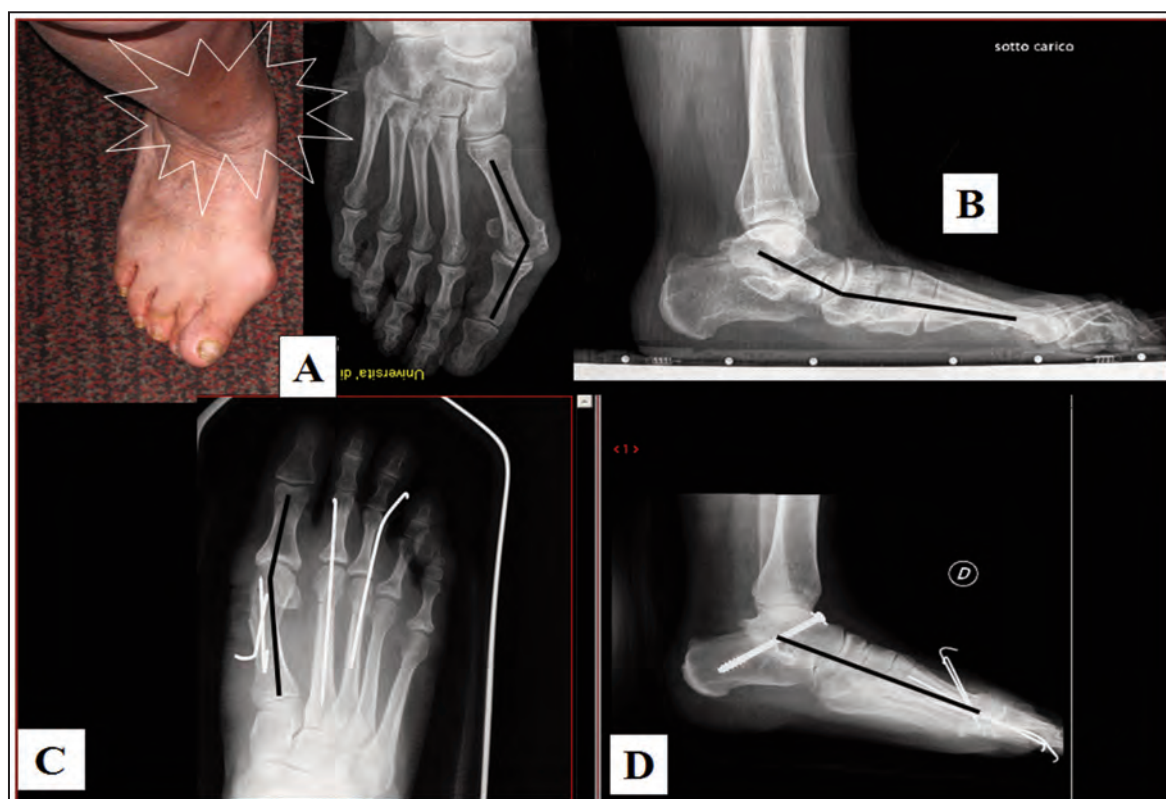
Case 6: 60-year-old female farmer with Triangular Forefoot and painful instability of the Sub-Astragalic articulation by bilateral flatness (with architectural collapse of the back-foot) - (A -B). The X-ray control of the left foot post-intervention of: "reinforced Arthrodesis di Grice + Elongation of the Achilles tendon + osteotomy of the I-II-III Metatarsal in closing and realignment of the metatarsal fan" documents the reconstitution of the vault and standardized closure of the metatarsal fan (C - D).
